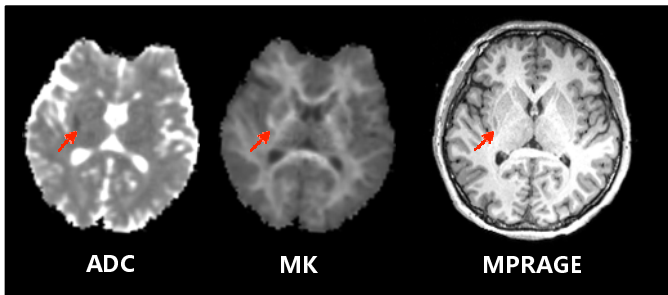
32y male patient with infarct in the right external capsule. DWI and DKI were acquired at 3h after onset. The infarct lesion shows a low ADC value and a high MK value.
